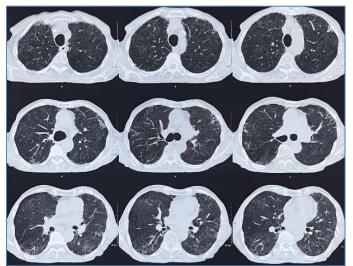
HRCT thorax showing bilateral peripheral subpleural interstitial reticular and linear opacities with emphysema in upper and middle lobe
